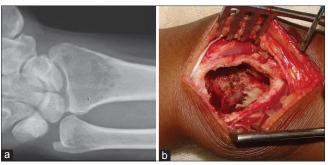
(a) X-ray anteroposterior view of wrist showing intraosseous giant cell lesion distal end radius and (b) peroperative photograph showing the size of window for a giant cell tumor of the distal radius; it is as large as the size of the lesion
